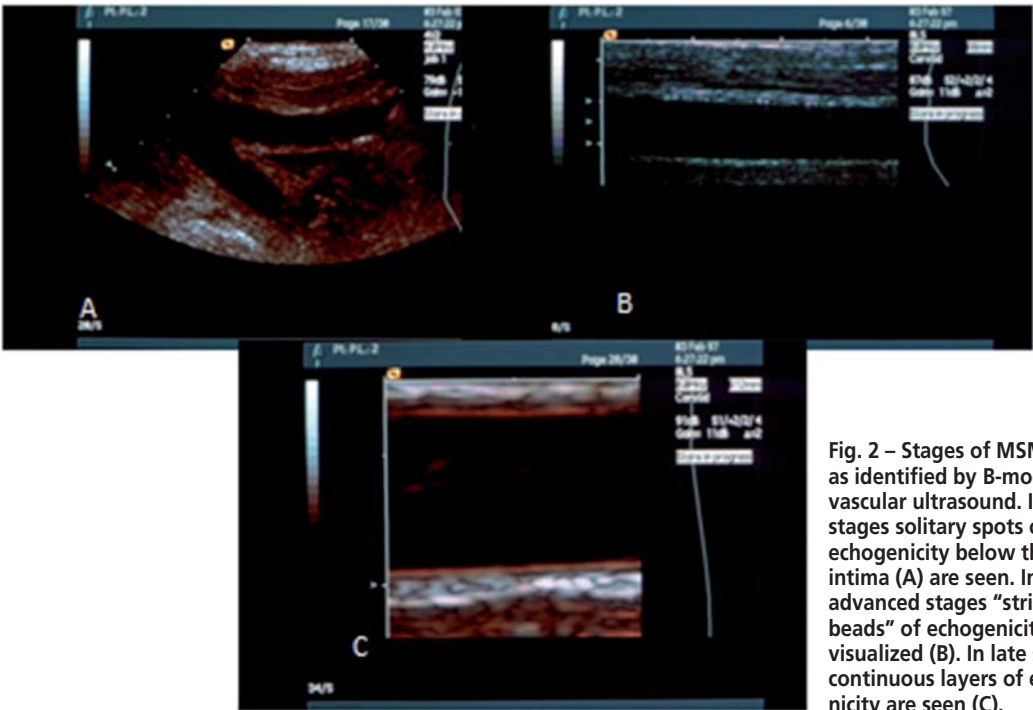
Stages of MSM as identified by B-mode vascular ultrasound. In early stages solitary spots of high echogenicity below the intima (A) are seen. In more advanced stages “strings of beads” of echogenicity are visualized (B). In late stages continuous layers of echogenicity are seen (C).
